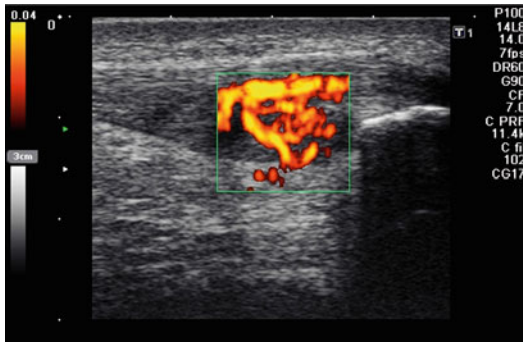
Power Doppler ultrasound showing a patellar tendinopathy with a significant enlargement of the patellar tendon and substantial neovascularisation at the proximal patellar pole
